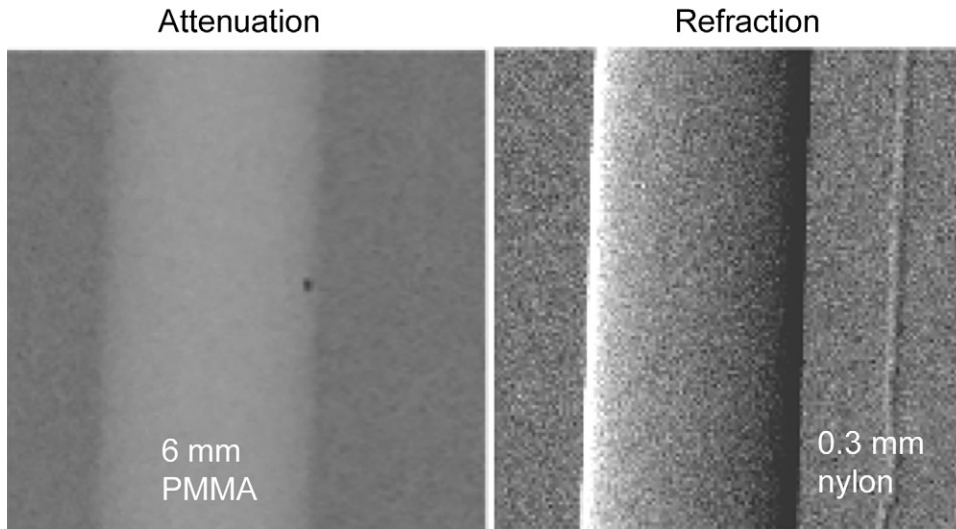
Attenuation-based radiograph and phase-contrast refraction radiograph of a poly(methyl methacrylate) (PMMA) rod and a 0.3-mm nylon filament immersed in a 5-cm-thick water bath. The images were obtained at 60 kVp with a glancing angle interferometer. The computed radiation dose is 2 mGy absorbed dose. The thin filament is invisible on the conventional image (left) but has good contrast with refraction (right).
